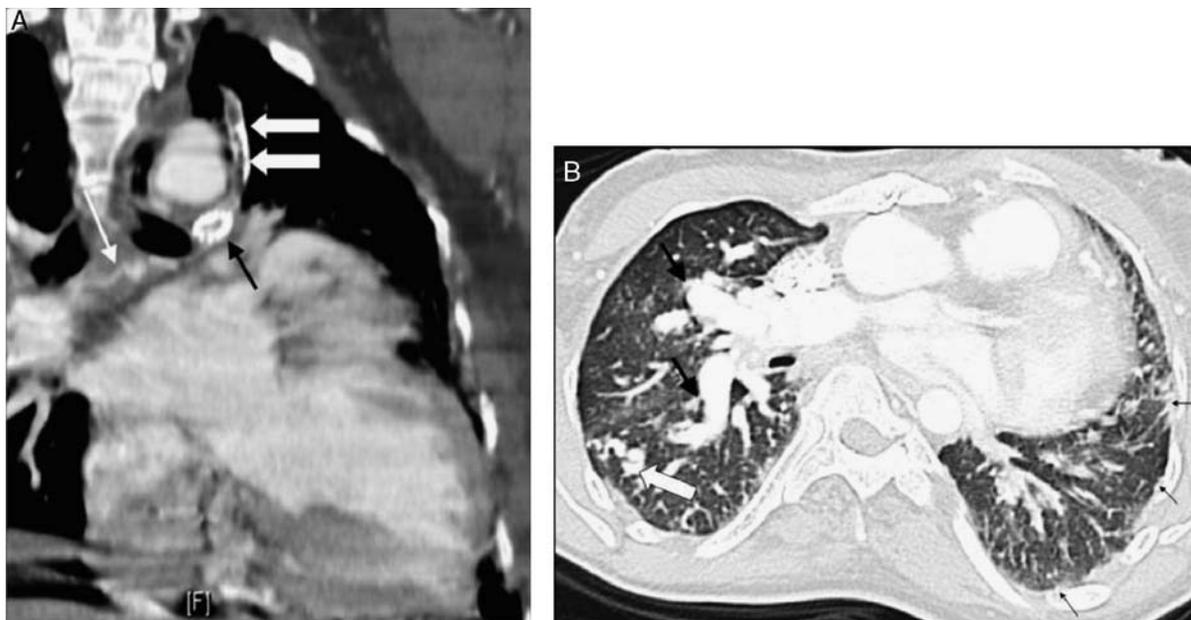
A 32-year-old-woman with tetralogy of Fallot after left Blalock-Taussig shunt and stenting of the left pulmonary artery. A, Coronal reformat from a contrast-enhanced CT shows an occluded left Blalock-Taussig shunt (thick white arrows) entering an occluded left pulmonary artery stent (black arrow). Multiple aortopulmonary collateral arteries (MAPCAS) are present (thin white arrow). B, Lung windows demonstrate abnormal asymmetric pulmonary perfusion prominent on the right (black arrows) and diminished on the left. A poststenotic dilated peripheral vessel in the right lower lobe (thick white arrow) is a reflection of peripheral pulmonary artery stenosis. There is left-sided serrated pleural thickening (small black arrows) related to systemic collaterals.
